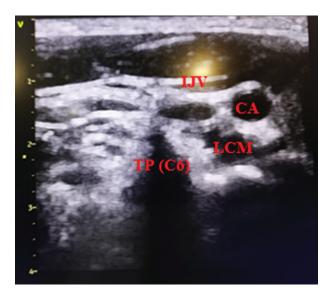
Structures viewed by ultrasound.
